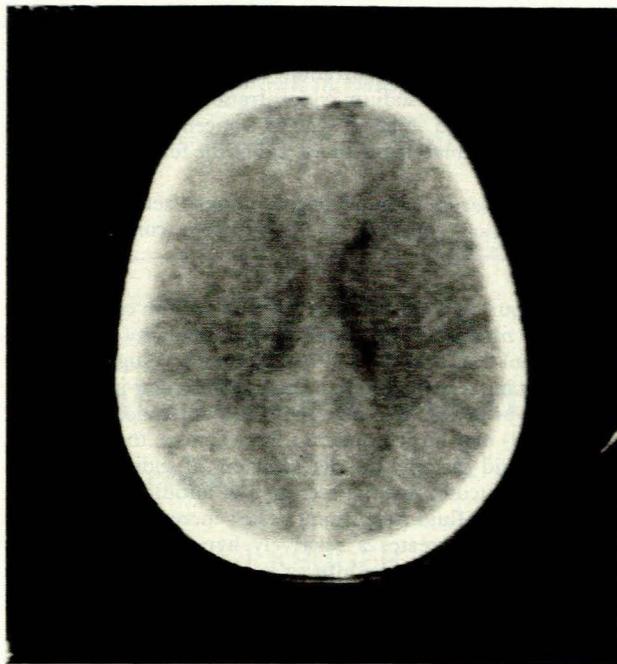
Unenhanced CT of the brain demonstrating relative effacement of the ambient cisterns, small lateral ventricles and low density of the centrum semiovale compatible with cerebral swelling and oedema.
